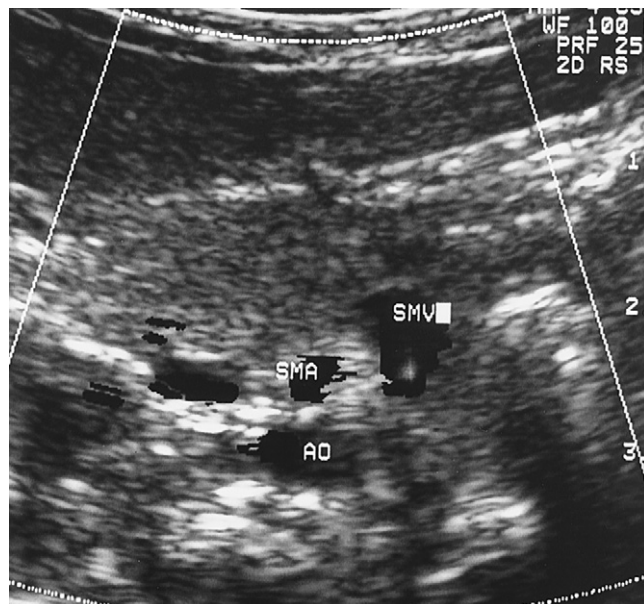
Color Doppler image of malrotation of a transverse upper abdomen. The abnormal position of the superior mesenteric vein (SMV) to the left of the superior mesenteric artery (SMA) can be seen just anterior to the abdominal aorta (AO). (Courtesy Marc S. Keller, MD, Yale University School of Medicine.)
